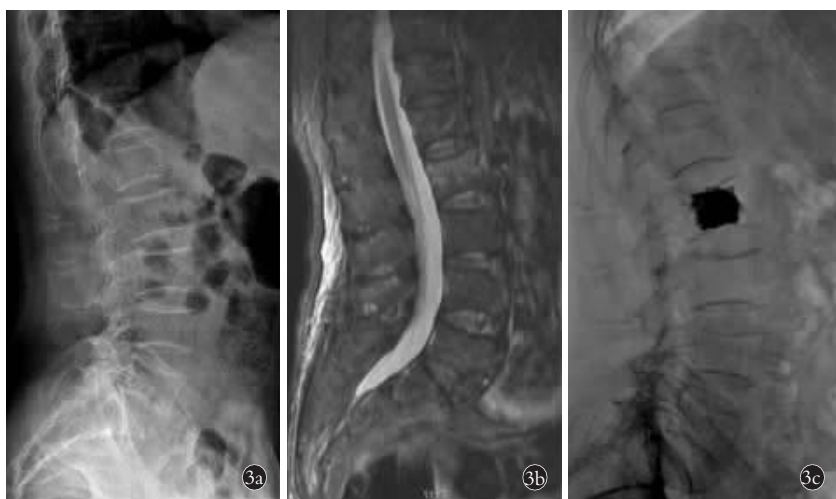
患者,男,67 岁,因腰痛 10 d 入院 3a. 术前 X 线检查提示 L<sub>2</sub> 椎体压缩性骨折 3b. 术前 MRI 提示骨折线位于椎体中上部 3c. 术后 X 线显示骨水泥充满整个椎体。通过计算发现骨水泥在骨折线区域分布范围>50%,纳入观察组
